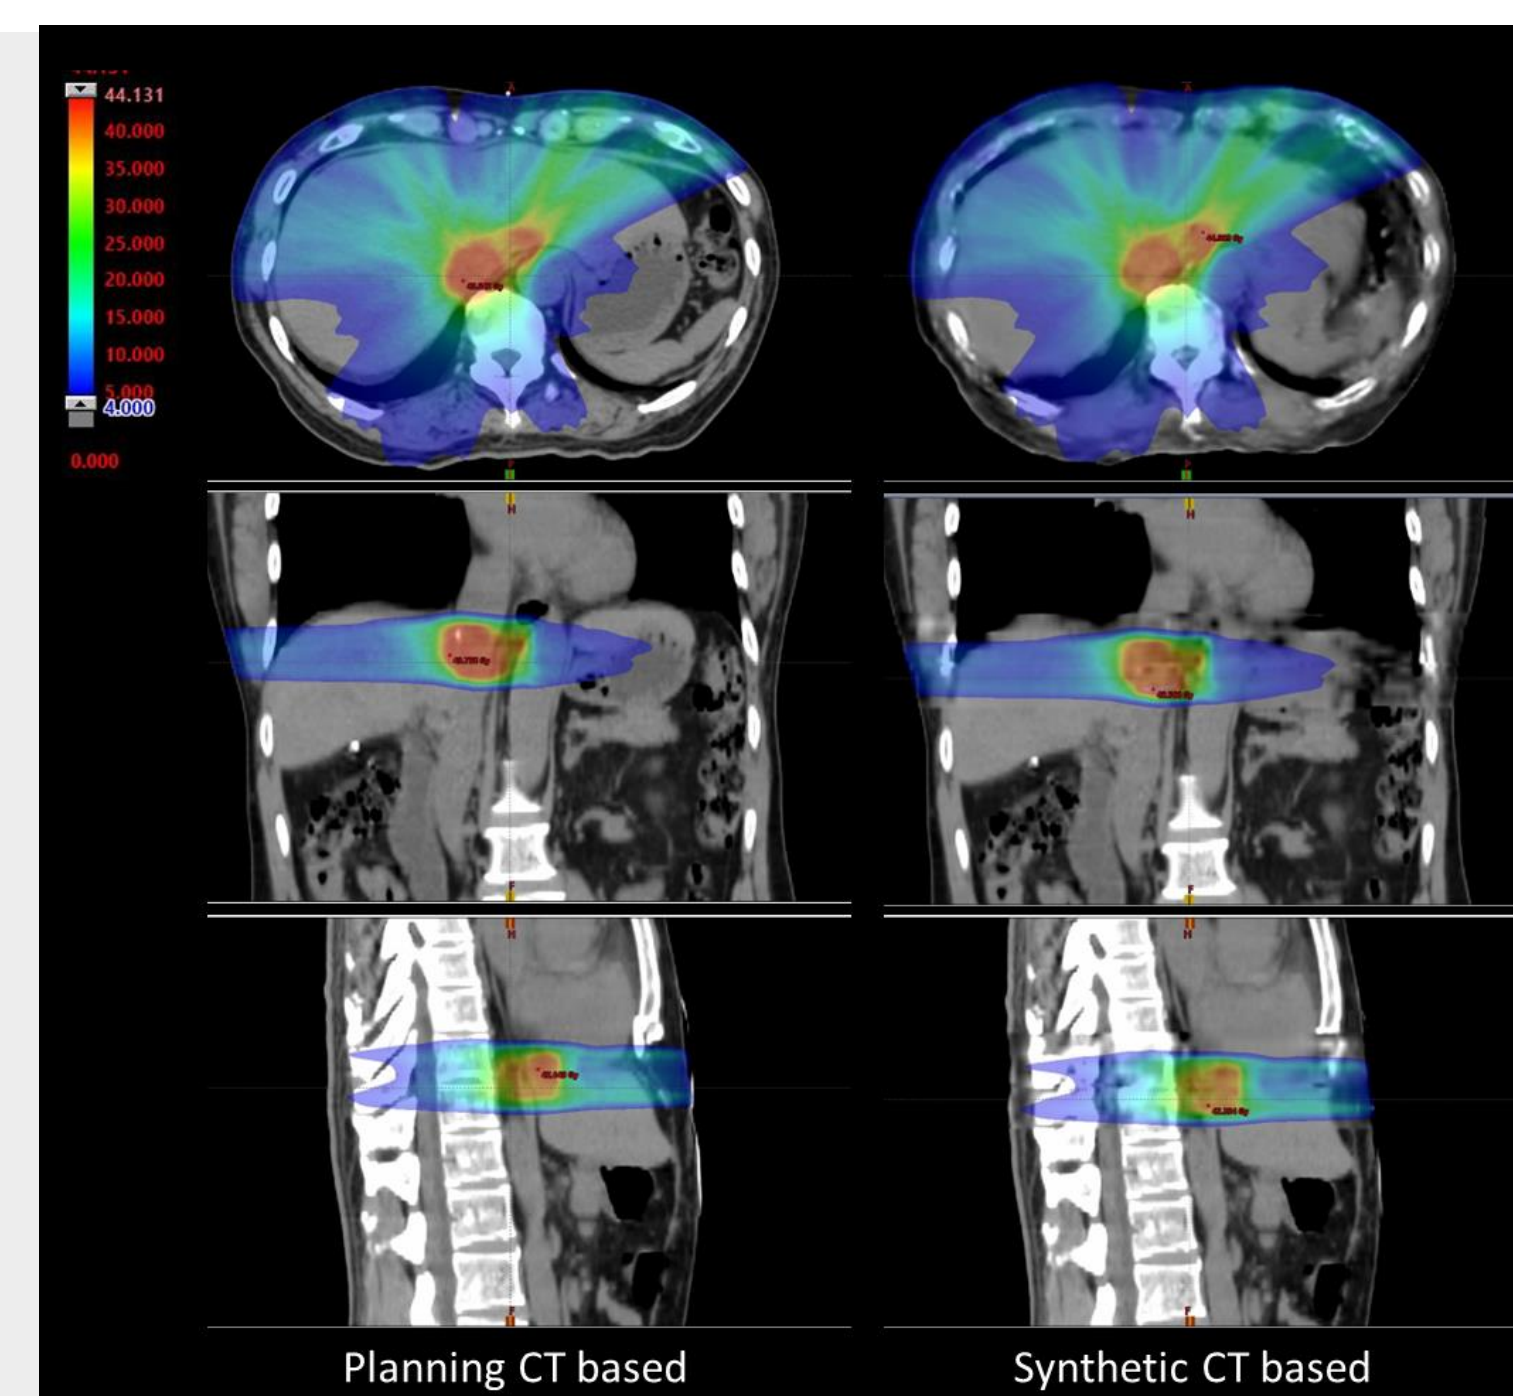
Comparison between planning CT-based and synthetic CT-based dose distribution of a test patient.
